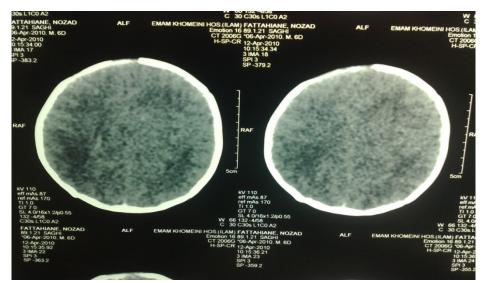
CT scan examination reflected a generalized brain edema.
